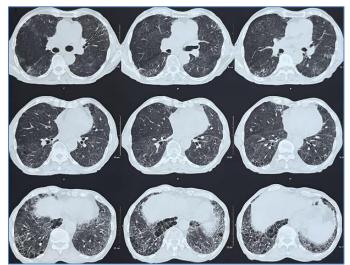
HRCT thorax showing bilateral peripheral subpleural interstitial linear, reticular opacites with tractional bronchiectasis and honeycombing in lower lobes
